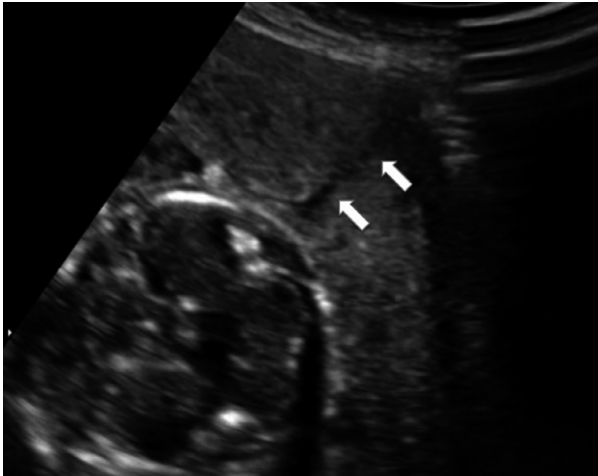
Suspected hypoechoic tract (arrows) seen on abdominal ultrasound through the myometrium following ultrasound-guided amnioinfusion located inferior to the initial abdominal skin incision.
